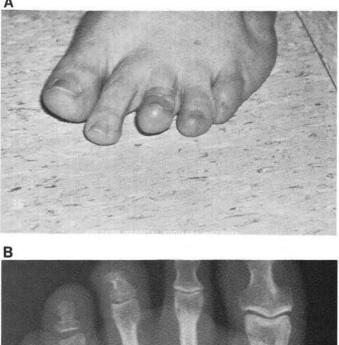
A. & B. Clinical and radiographic appearance of "floating" third and fourth toe two years after middle phalangectomies.
